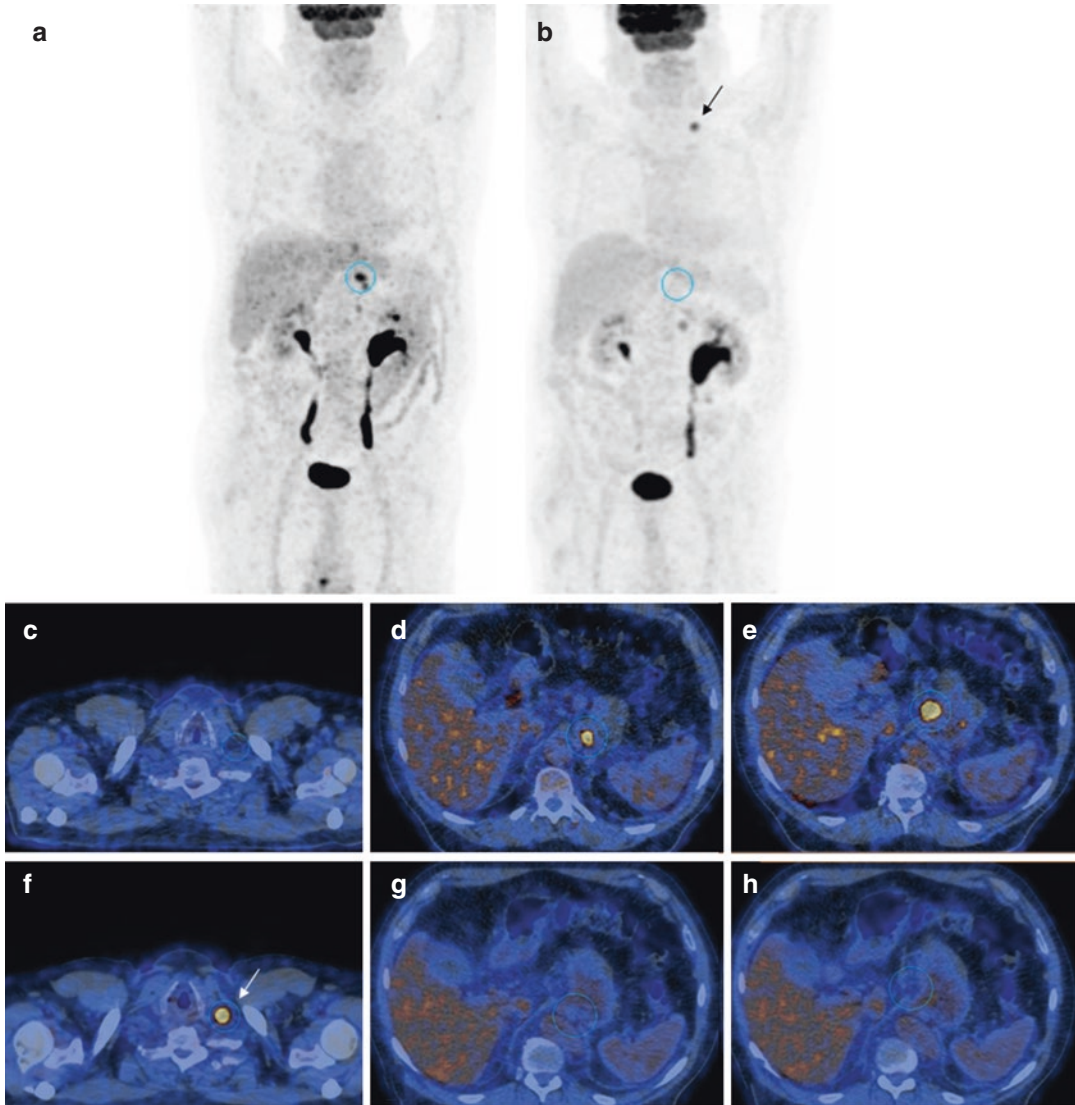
EGJ cancer before (a, c–e) and after CRT (b, f–h). MIP whole-body PET (a–b) as well as PET/CT images (c–h) before and after CRT demonstrate a complete response to treatment in perigastric lymph nodes and EGJ
